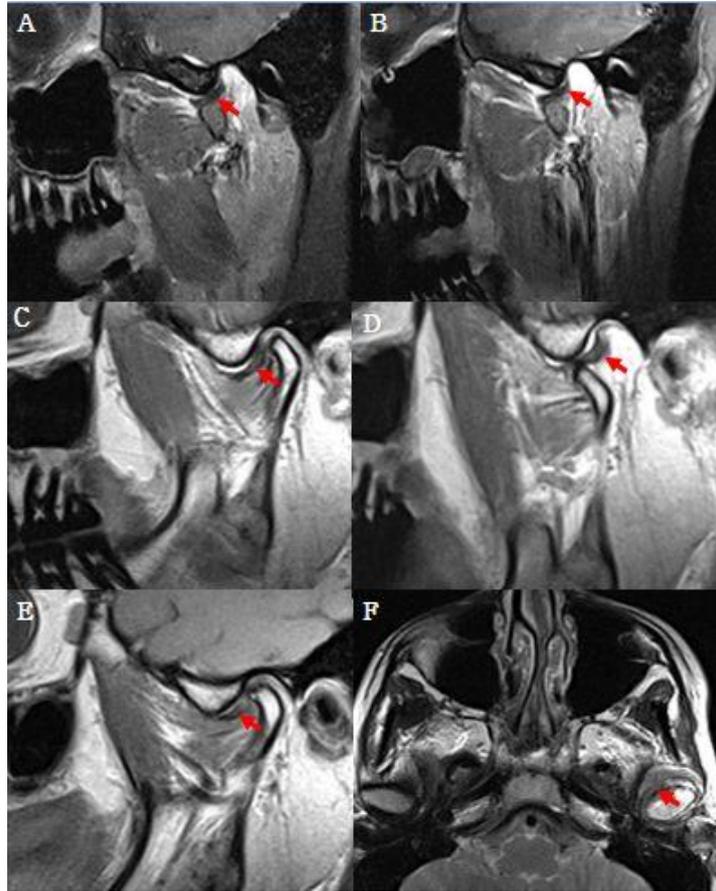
MRI findings of disc degeneration. MRI findings show degree of disc degeneration and synovitis. (A: Normal elasticity of disc, B: Degeneration of disc, loss of elasticity, C: Total anterior displacement, acute phase, D: Total anterior disc displacement with reduction acute phase, E: Total anterior disc displacement, chronic phase, F: Synovitis in juvenile TMJ)
